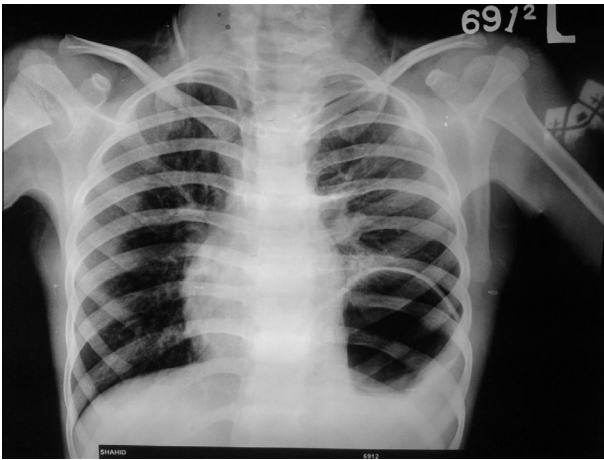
Chest X-ray showing raised left dome of the diaphragm, with well defined left diaphragmatic margin.
